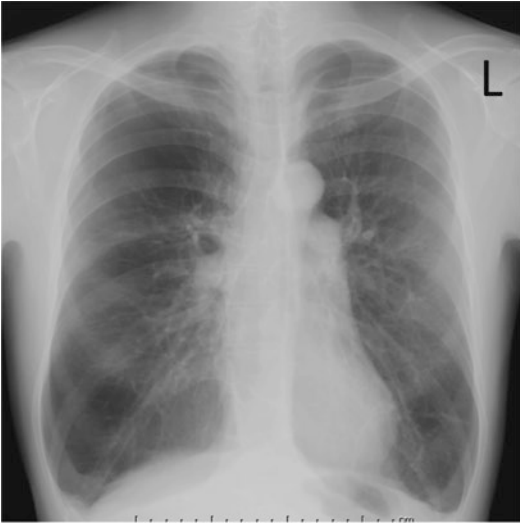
A chest roentgenogram of the proband shows hyperinflated lungs and bilaterally flattened hemidiaphragms (Miyahara et al. (2001) Intern Med. 40:336–40)
